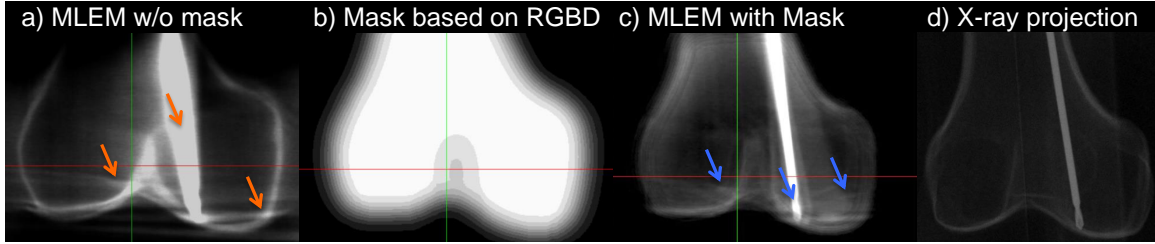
Reconstruction of a bone model with guide wire yields strong artifacts in and outside the structure (orange arrows in panel (a)) and a blurry, wide guide wire. Incorporating RGBD data (mask in (b)), results in an improved reconstruction quality (blue arrows in (c)) with clear guide wire tip. The log-normalized X-ray projection (d) shows the guide wire inside the bone.
